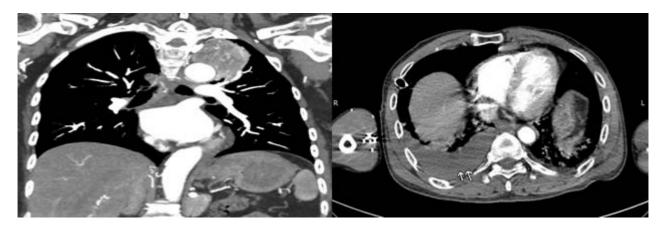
Significant extravascular findings that required radiological follow up or further investigation. Patient came to hospital with history of hemoptysis and computed tomographic angiography of the whole aorta shows no significant vascular finding. However, there is a large heterogenous enhancing mass at the apex of left lung. Lung metastasis from renal cell carcinoma was diagnosed after biopsy.
